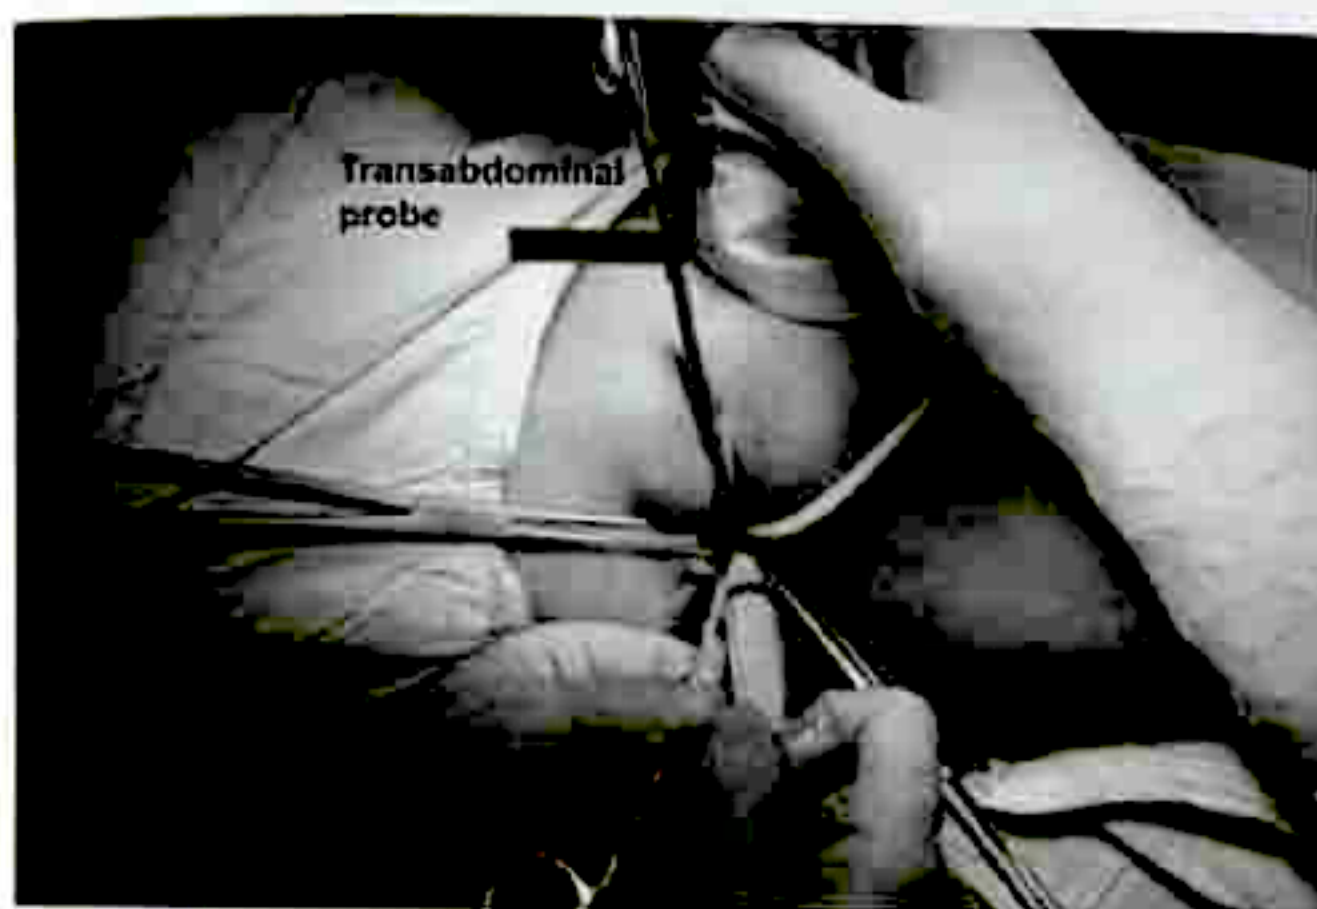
Ultrasound guided drainage of hematocolpos using a 10cc syringe, gauge 18 needle.
